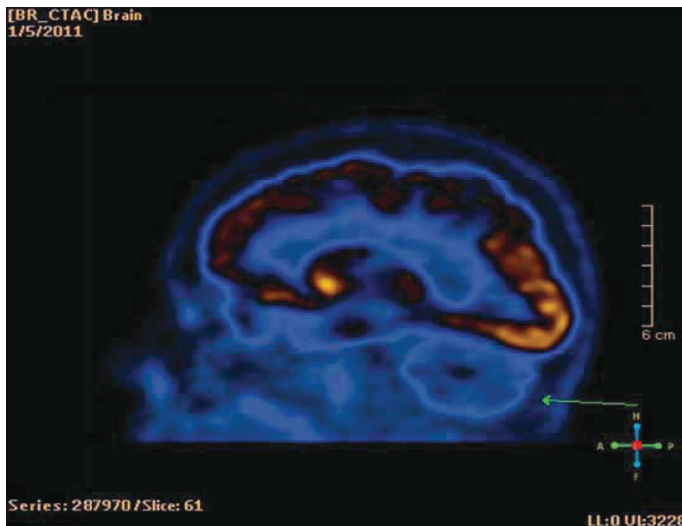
(18F)-FDG PET shows severe hypometabolism in cerebellum and mild - in parietal regions.
